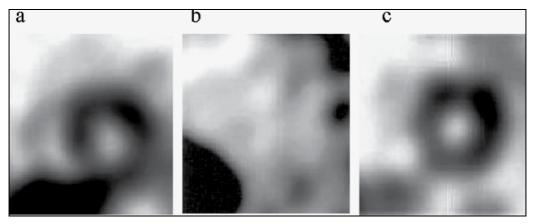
Short-axis views of ¹²³I-MIBG myocardial scintigraphy
